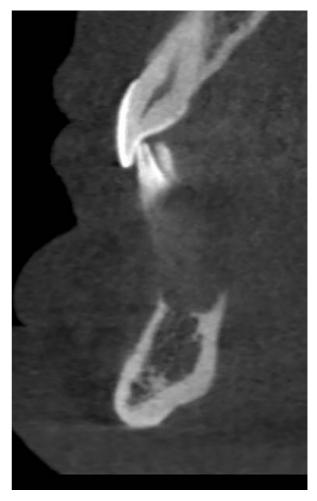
Sagittal cone beam computed tomography (CBCT) scan showing loss of cortical bone.
